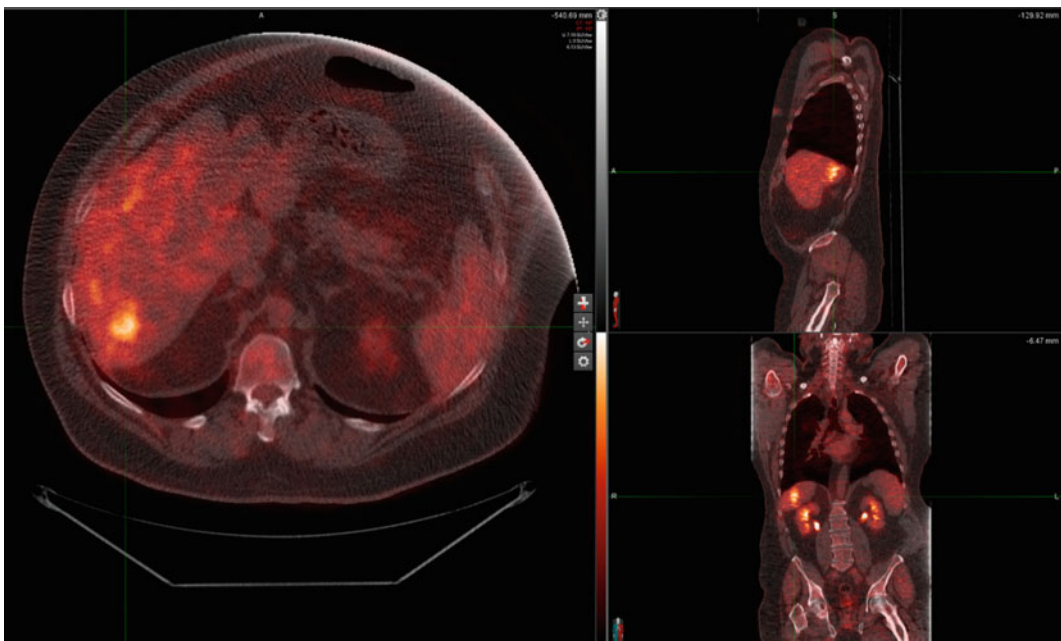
Fusion overlay of a FDG-PET CT scan for a patient undergoing liver SBRT. The hypermetabolic region is clearly visible in the liver and is useful for delineating the gross tumor volume (GTV) on the planning CT scan
